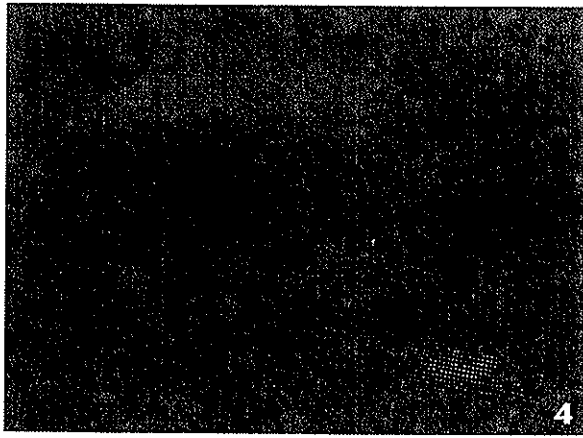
Ultrasound treatment (treating an area 2 times the size of the soundhead at a speed of approximately 4 cm/sec) using ultrasound gel.
